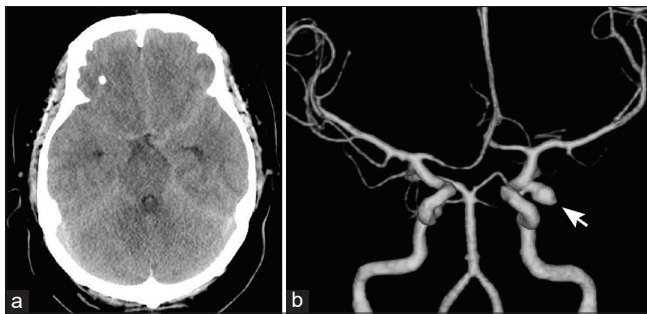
Preoperative axial computed tomography (CT) (a) demonstrating subarachnoid haemorrhage. Three-dimensional reconstructed CT angiogram (b) showing a large internal carotid-posterior communicating artery aneurysm with a bleb (arrow).
